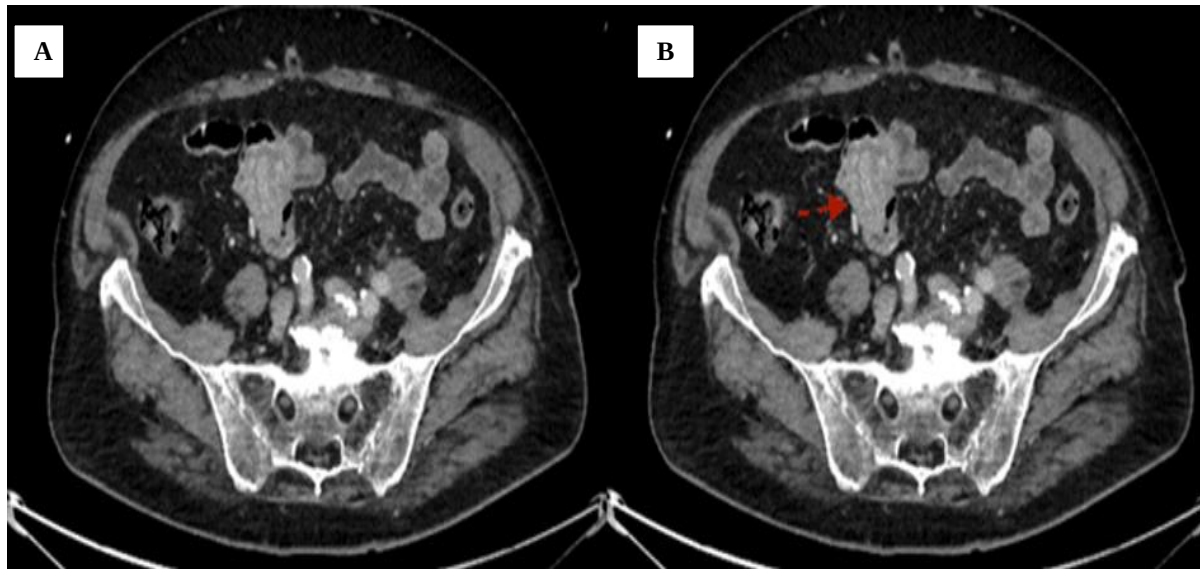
Jejunojejunal Intussusception with Sandwich Sign on Axial CT. Axial contrast-enhanced CT images showing a right paraumbilical jejunojejunal intussusception with the classic "sandwich sign," characterized by concentric bowel layers surrounding invaginated mesenteric fat and vessels. (A) Unannotated image and (B) the "sandwich sign" is indicated by a red arrow.
